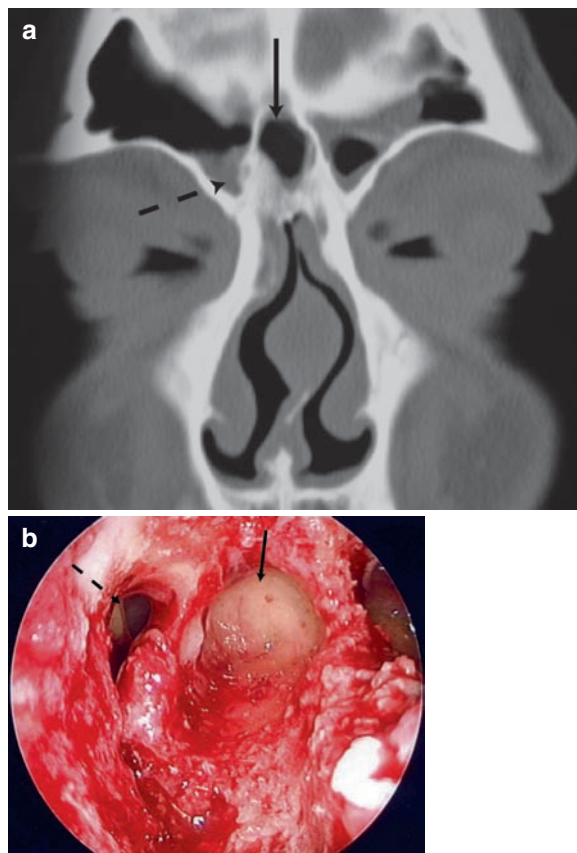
(a) Coronal CT scan shows a large intersinus septal cell (*solid arrow*) narrowing and pushing the frontal ostium laterally (*dashed arrow*). (b) The intraoperative picture shows how this cell (*solid arrow*) obstructs and narrows the right frontal ostium (*dashed arrow*)
